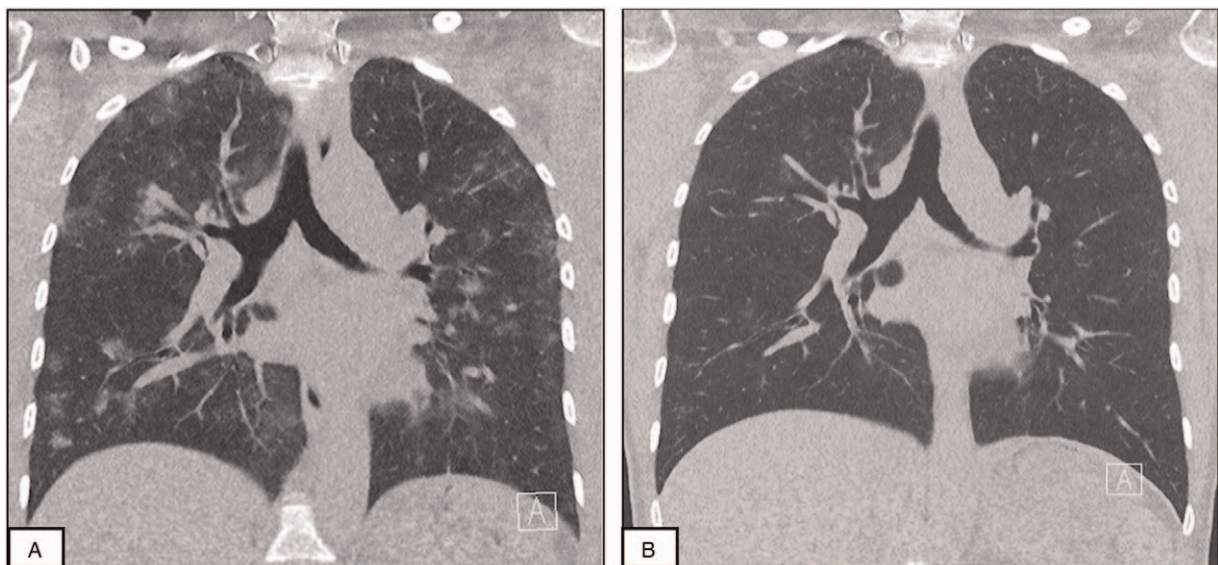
Patient 1: evolution with progressive healing of lung infiltrates on chest ultra-low dose CT. Progressive healing from day 1 (A) to day 15 (B) of typical bilateral infiltrates with subpleural distribution.
